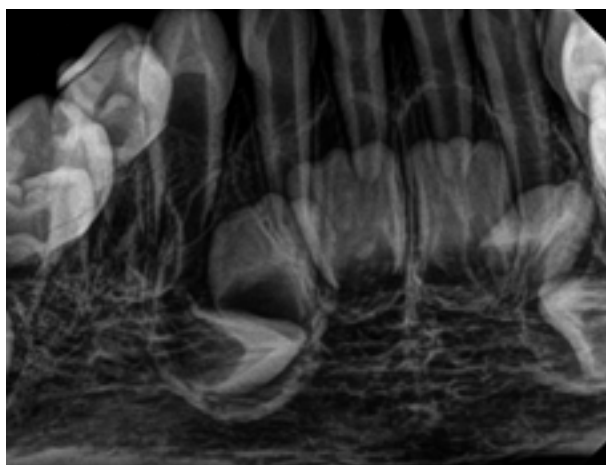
Periapical radiograph depicting the developing mandibular permanent anterior teeth.
